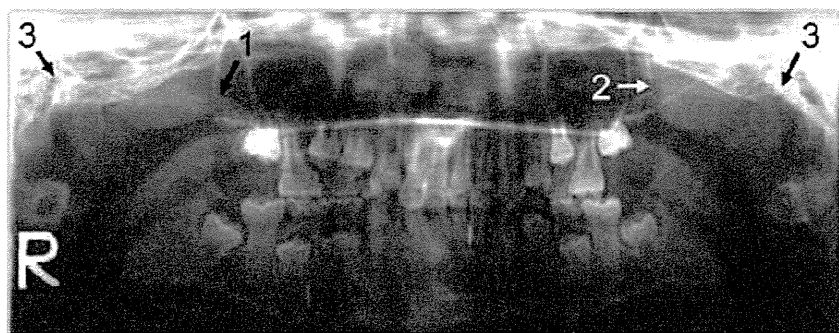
Panoramic radiograph at the initial visit (age 8 years, 9 months). Widening of the right coronoid process (arrow 1) and elongation of the left coronoid process (arrow 2) were seen. Mild flattening of the bilateral condylar heads was suspected (arrows 3).
